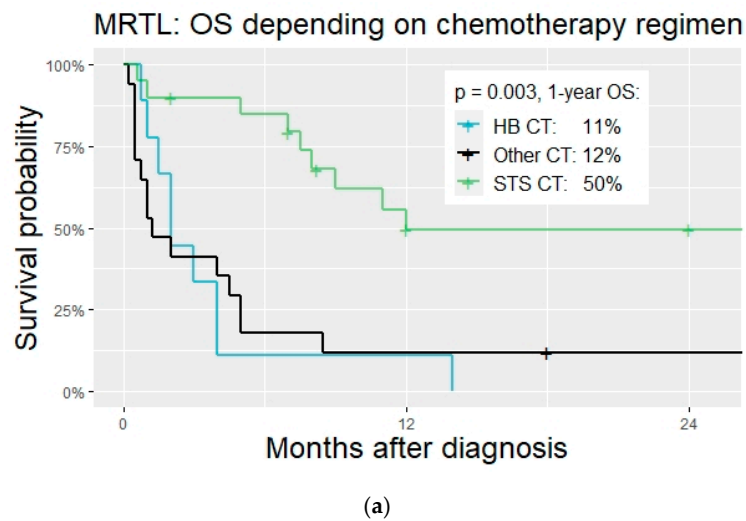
OS of patients with MRTL and SCUD according to different applied CT regimens. (a) OS of patients with MRTL and different CT regimens (b) OS of patients with SCUD and different CT regimens.
